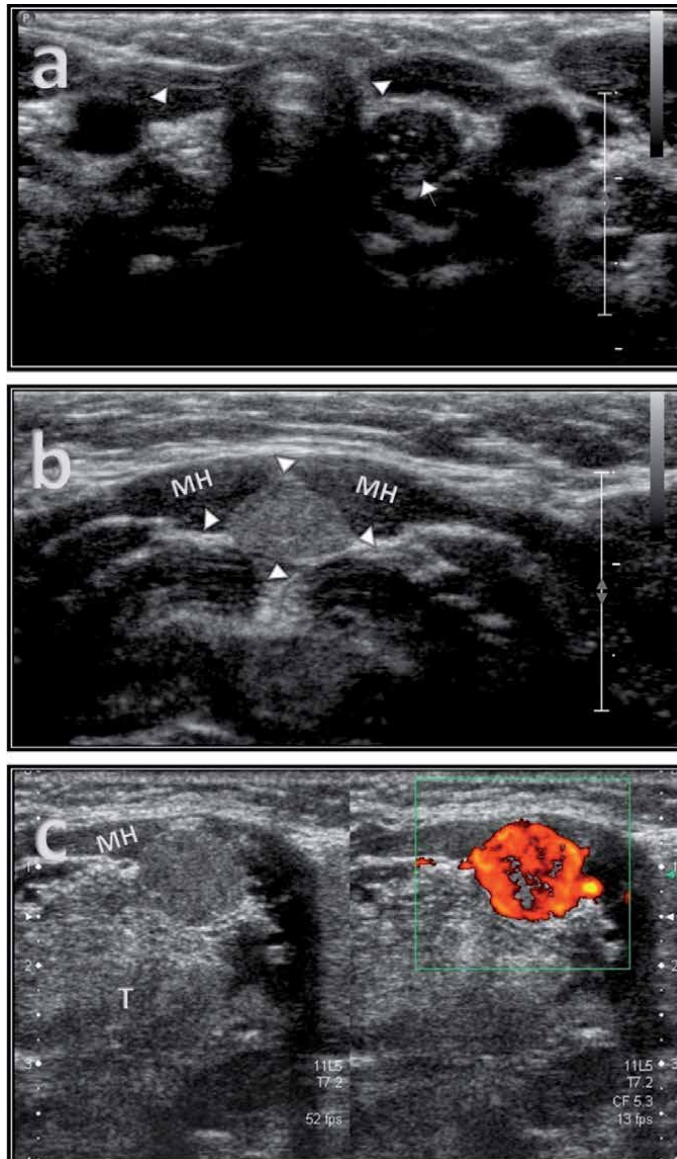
(a) Athyreosis, empty thyroid lodge. The arrowheads indicate echogenic triangles, representing ultimobranchial and connective tissue residue. The esophagus is more prominent (arrow). (b) The floor of the mouth superficial ultrasound examination, the lingual ectopic thyroid is seen as similar as normal thyroid echogenicity. (c) Another case of lingual ectopic thyroid is seen as ovoid, isoechoic, and hypervascular. (MH: Mylohyoid muscle, T: Tongue) (Courtesy of Prof Dr. Suat Fitoz from his archive. Department of Pediatric Radiology, Ankara University School of Medicine, Ankara/Turkey).
